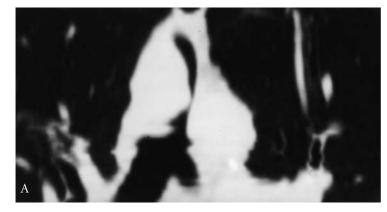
Adenoid cystic carcinoma. A, Two-dimensional reformatted computed tomography image of the distal trachea and carina demonstrates a smooth intraluminal mass arising from the right lateral wall of the trachea. B, T1-weighted coronal magnetic resonance imaging through the trachea and carina in the same patient demonstrates a soft tissue mass in the distal trachea, consistent with adenoid cystic carcinoma.
